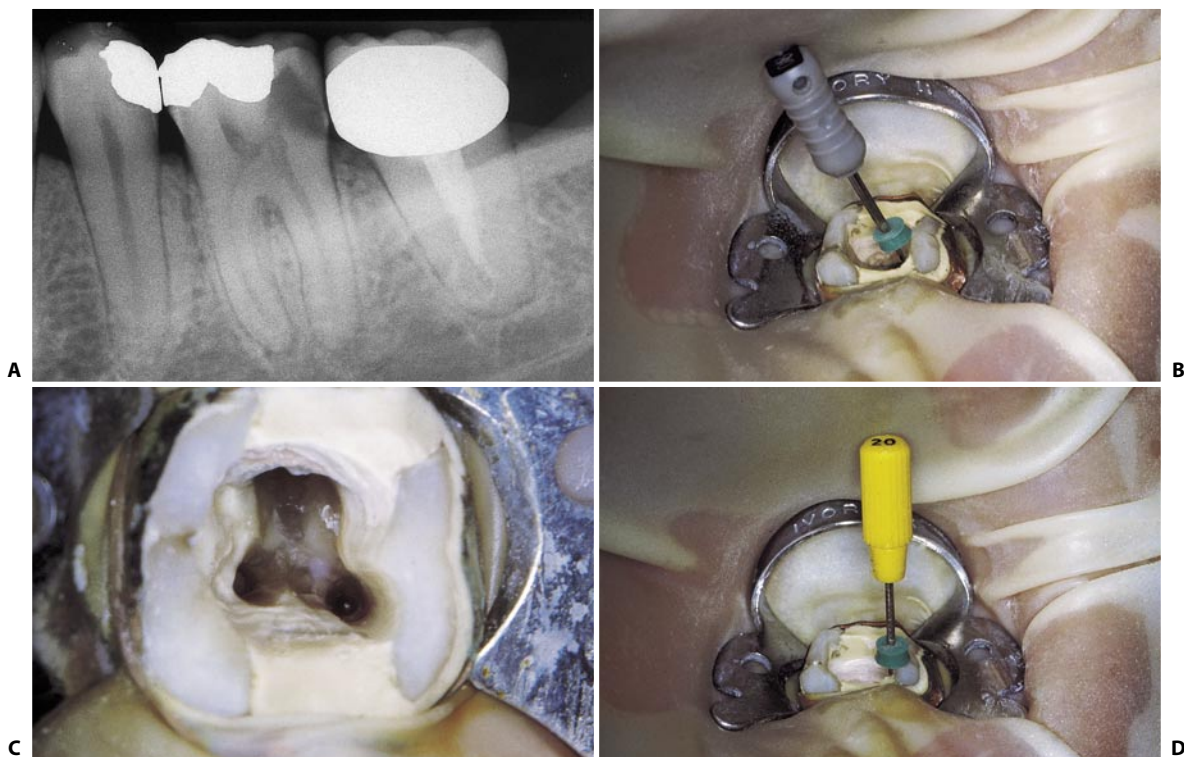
A. Preoperative radiograph of the lower left first molar. Note the curvature of the coronal one third of the mesial root. B. The # 08 file, introduced in the mesiobuccal canal, indicates that the curvature is directed not only distally, as appreciated radiographically, but also lingually. C. The access cavity has been extended mesially and buccally, at the expense of the mesiobuccal cusp. D. This instrument, a # 20 file, has straight-line access to the apical one third of the root canal.
